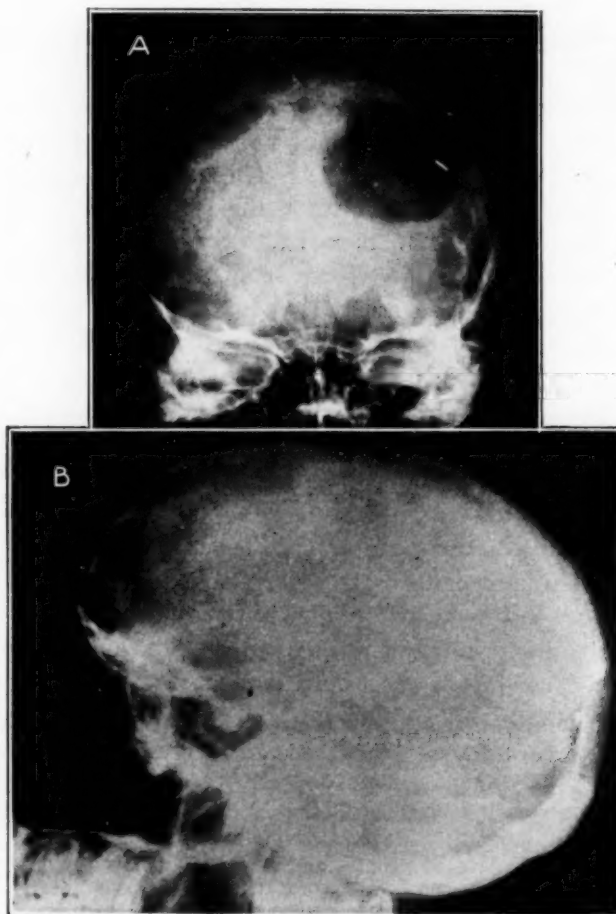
(case 3).—Roentgenograms of the skull, showing large circular defect in the occiput. Although the bony defect is to the left of the midline, the available evidence indicates damage to both occipital lobes.
